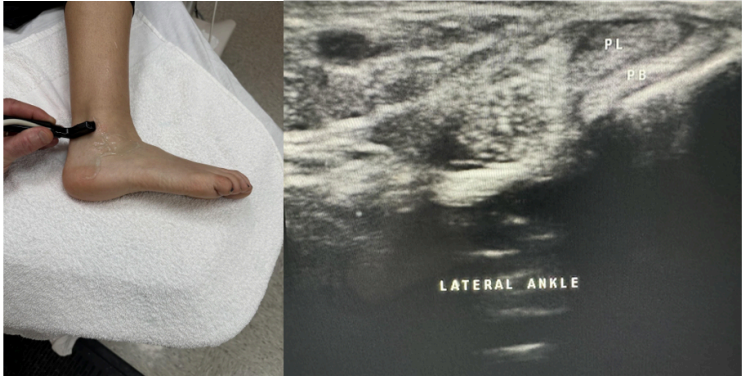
Side-by-side pictures of the transducer position and transverse image of peroneus brevis (PB) and peroneus longus (PL). The abbreviations given here and labeled on the ultrasound image represent the corresponding structures.
